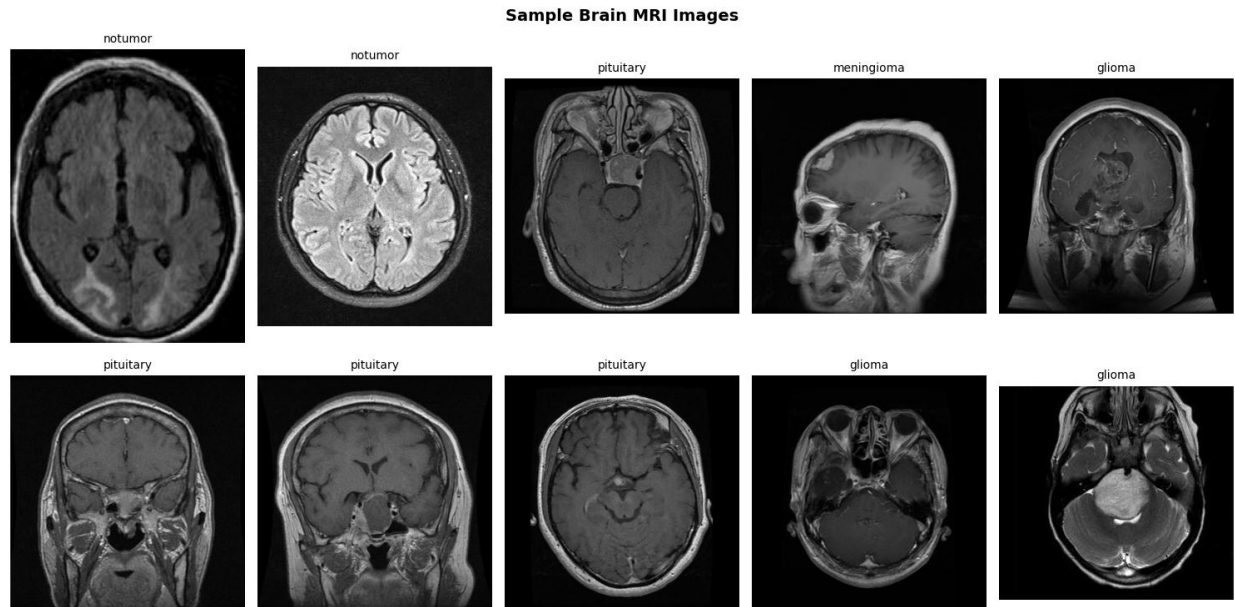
Representative sample MRI images from each tumor class. Significant morphological, intensity, and perspective variation is observable across and within classes, highlighting the classification challenge.
